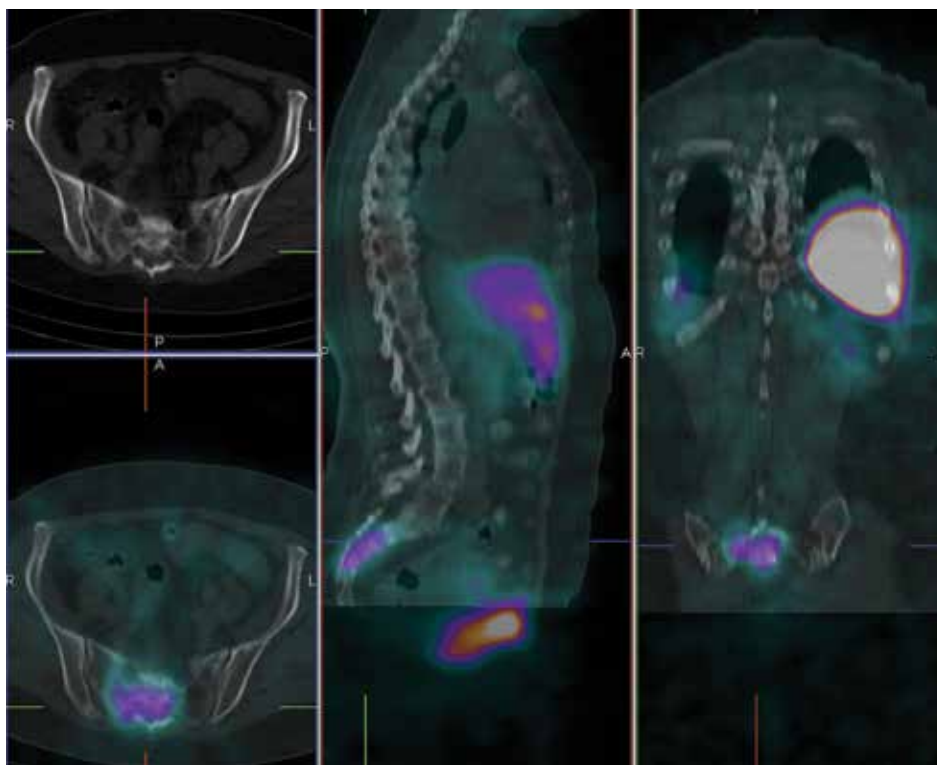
A 65-year-old female with medullary thyroid carcinoma (case number 4). ^{99m}Tc -EDDA/HYNIC-TOC SPECT/CT revealed distant metastasis in sacrum. SPECT/CT, single photon emission computed tomography/computed tomography
